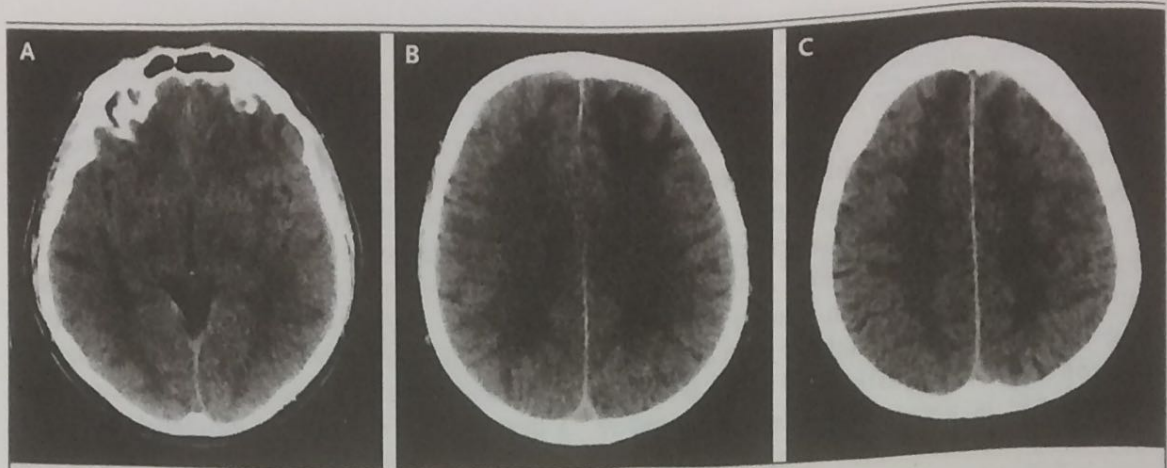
CT Scans of the Head at Presentation.
